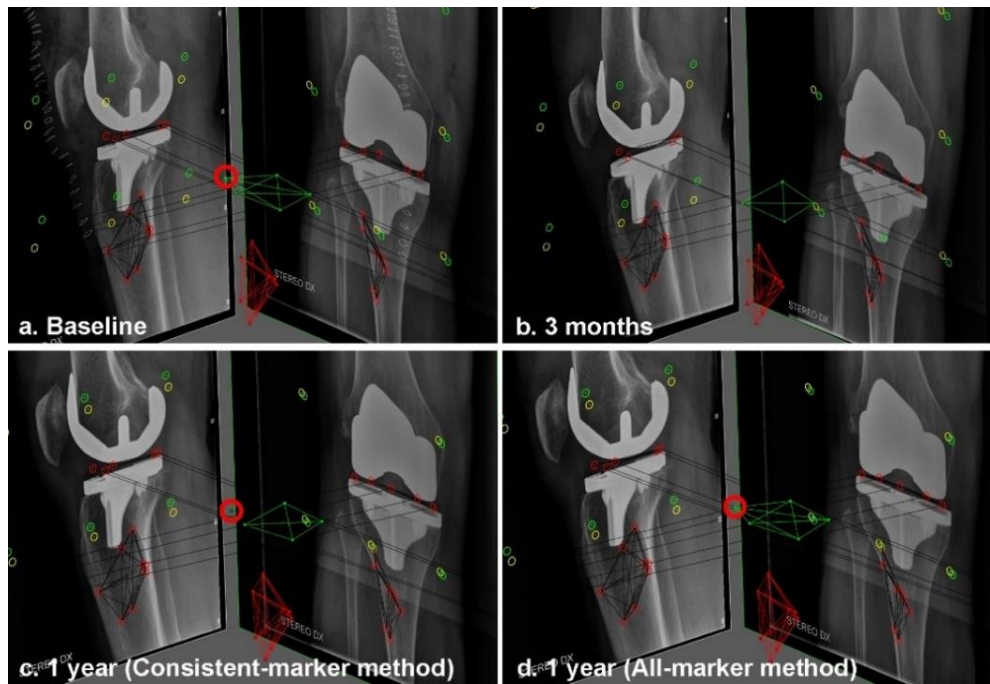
RSA examinations showing the baseline (a) and 3 months (b) follow-up examination of a patient. At 3 months, the anterolateral marker (red circle) in the PE insert is overprojected by the implant in the lateral radiograph. Using the consistent-marker method, only 4 of the 5 markers in the PE insert are selected at the 1-year follow-up (c) for the migration calculation (as these are the markers used at the 3 months examination). With the all-marker method, all 5 available markers that can be matched to the reference examination are used for the migration calculation at the 1-year follow-up (d).
